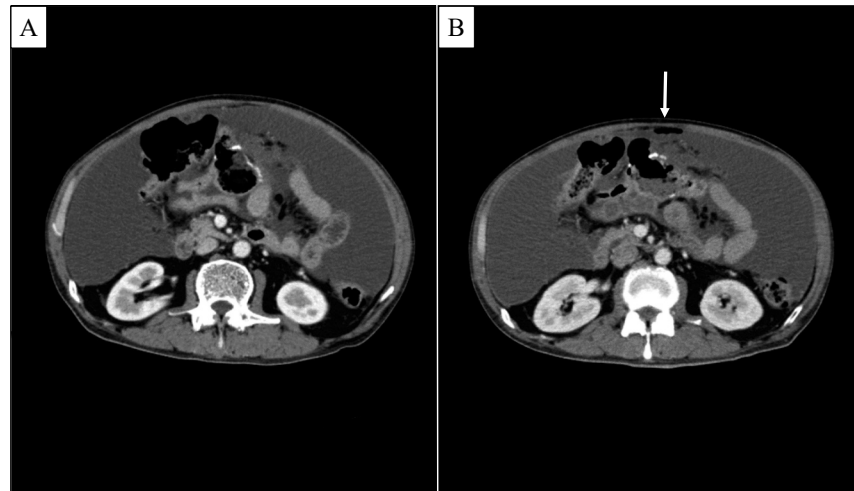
Computed tomography images of the patient with gastrointestinal perforation. Image taken on the first (A) and second (B) day of hospitalization. Images on the second day of hospitalization show free air near the anastomotic site (shown by an arrow).
